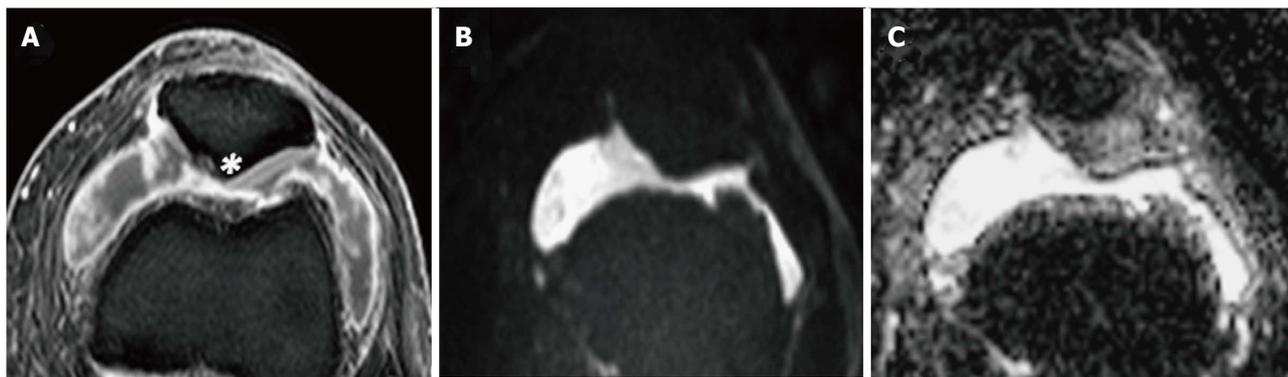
Synovial fluid evaluation with diffusion-weighted imaging. In a 42-year-old woman with RA and knee swelling. A: Axial post contrast fat-suppressed TSE T1-weighted sequence shows articular fluid and synovial enhancement; B, C: DWI with a b value of 900 s/mm² and corresponding ADC map confirm the presence of an effusion without significant restriction of free water motion (ADC: $2,8 \times 10^{-3}$ mm²/s) consistent with transudate due to rheumatoid arthritis, as confirmed by arthrocentesis. In this case, DWI helps to exclude infection. Note the presence of a prominent chondral erosion near to patellar apex (asterisk on A). DWI: Diffusion-weighted imaging; RA: Rheumatoid arthritis; ADC: Apparent diffusion coefficient.
